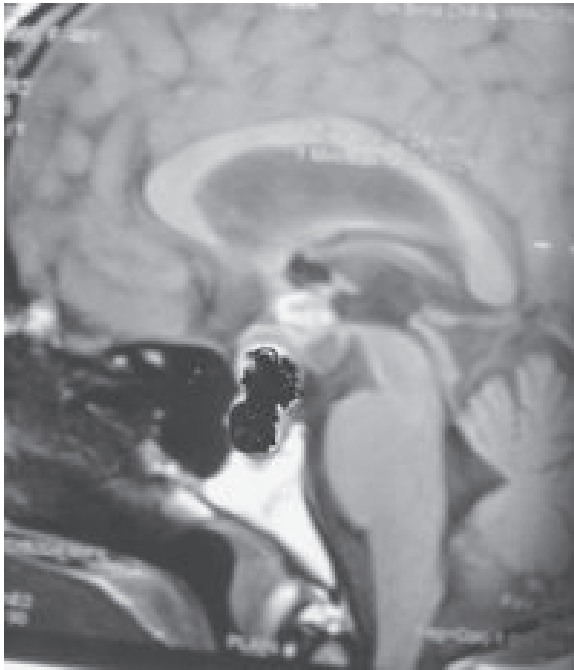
Postoperative MRI of brain with contrast (sagittal view)
